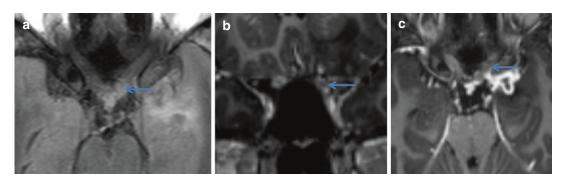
A 23-year-old male presents with insidiousonset left-sided hemianopia. Axial FLAIR (a), postcontrast T1-weighted fat-suppressed coronal (b) and axial
